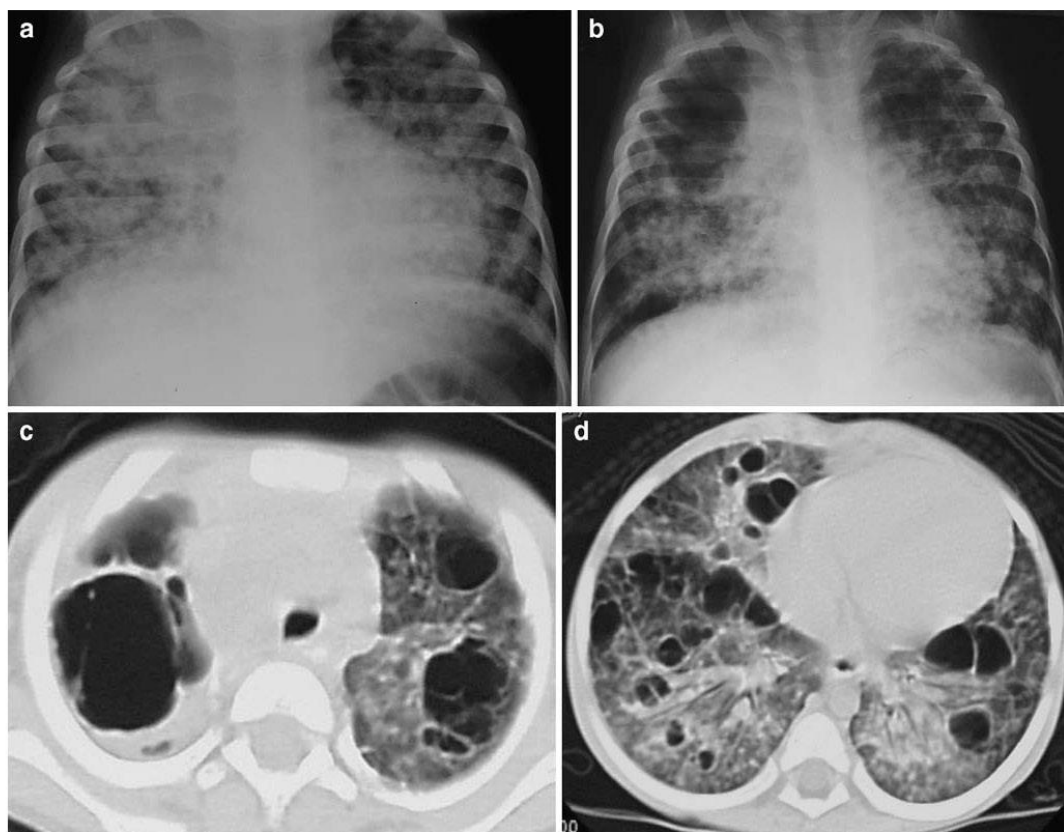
A 2-year-old HIV-negative girl (CP) with severe adenopathy, clubbing and malnutrition and a positive TB contact. a The initial chest radiograph demonstrates bilateral airspace disease with areas of confluence and some early breakdown. b A follow-up chest
